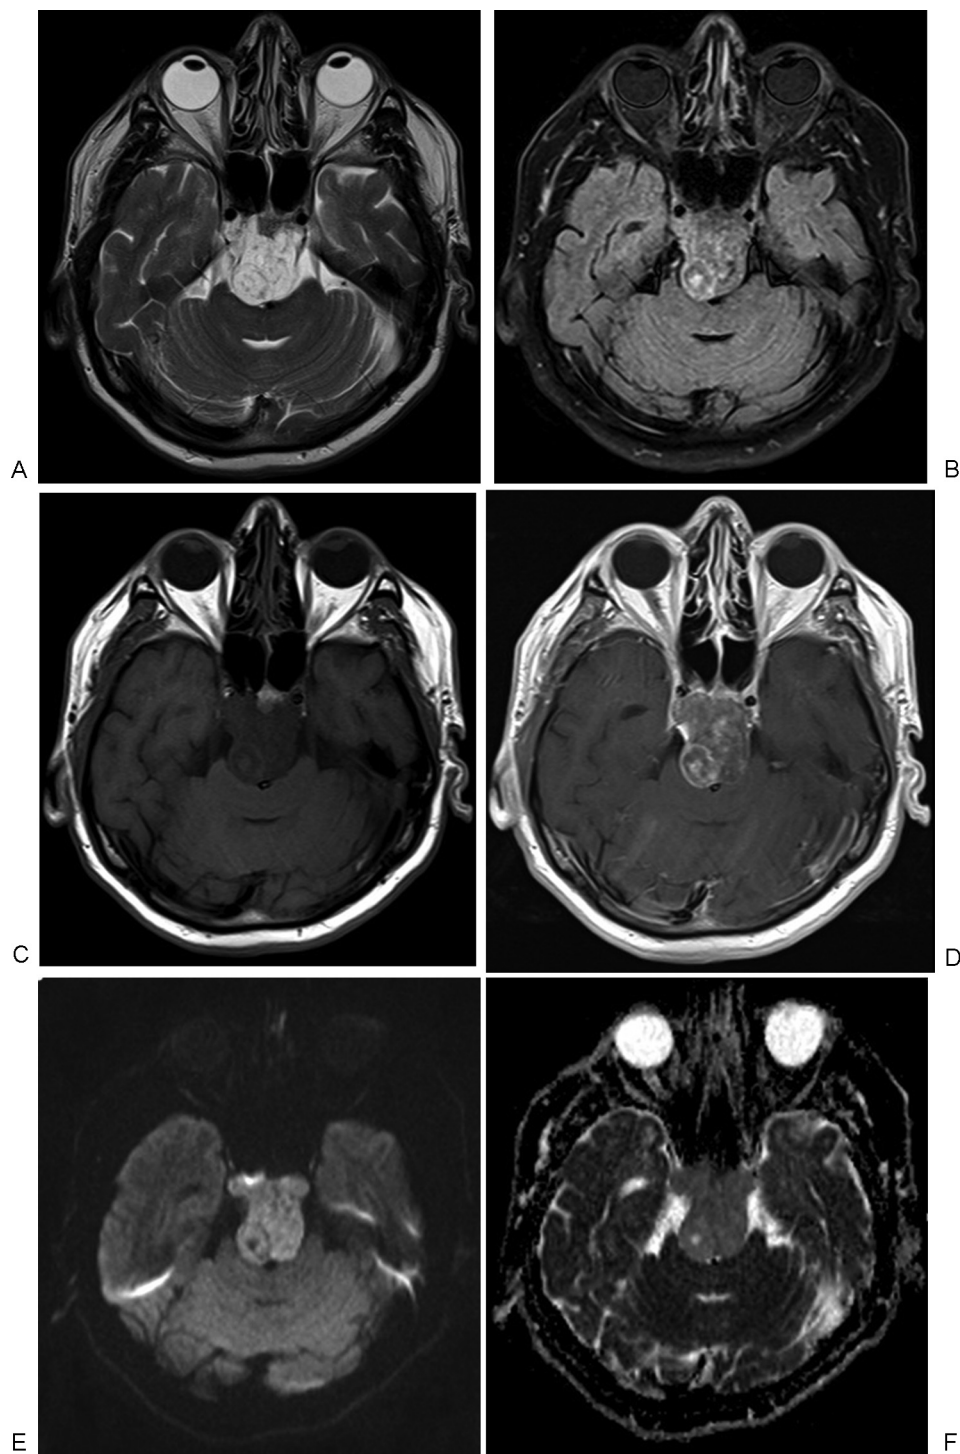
Preoperative magnetic resonance images of a 40-year-old male with typical chordoma. (A) Axial T2-weighted (W) image and (B) fluid-attenuated inversion recovery image show a high signal intensity clival mass arising from the clivus, expanding prepontine cistern, and compressing the pons. (C) Axial T1W image and (D) postcontrast T1W image show that the mass enhances in a mild heterogeneous pattern. The mass is very well delineated on the diffusion-weighted trace image (E) and on the corresponding apparent diffusion coefficient map (F).
